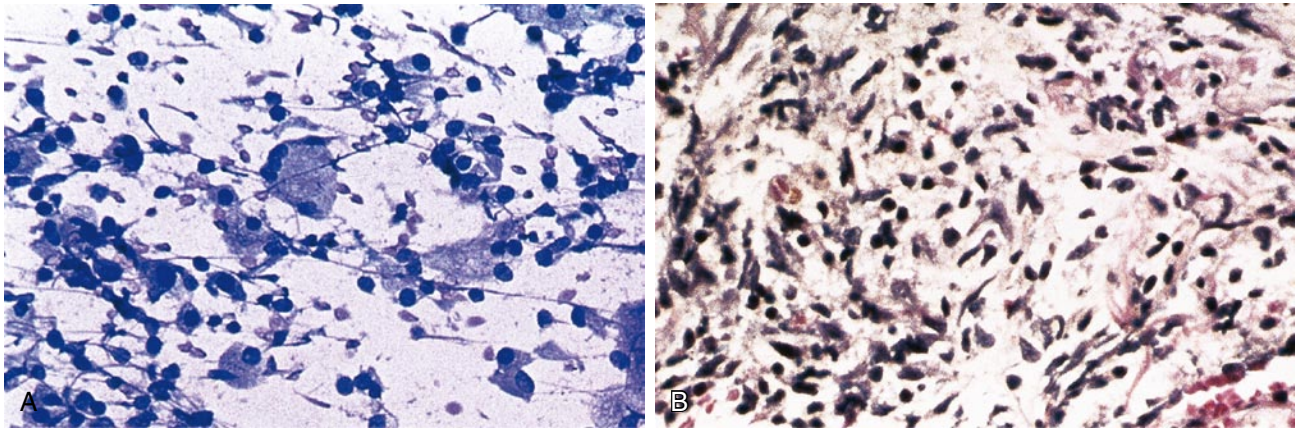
Organizing pneumonia (fine-needle aspiration [FNA]). Some pneumonias respond slowly to antibiotic treatment; such lesions may mimic a neoplasm radiographically. A, Smears typically show an admixture of lymphocytes and foamy macrophages. B, Cell block preparations show fragments of granulation tissue composed of loosely arranged fibroblasts admixed with chronic inflammatory cells.
